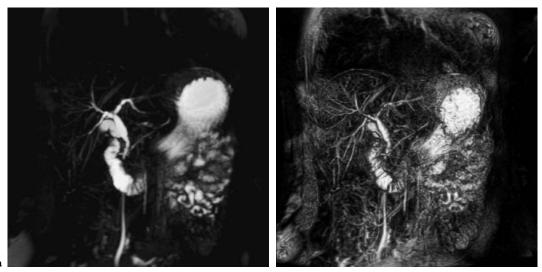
Primary sclerosing cholangitis. Coronal MIP 3D heavily T2-weighted MR cholangiogram (a) demonstrates diffuse focal strictures of both the intrahepatic and particularly the extrahepatic bile ducts. MR VR with a large threshold (b) better visualizes the entire biliary system and characterizes the strictures showing thickening and irregularities of the ductal wall
